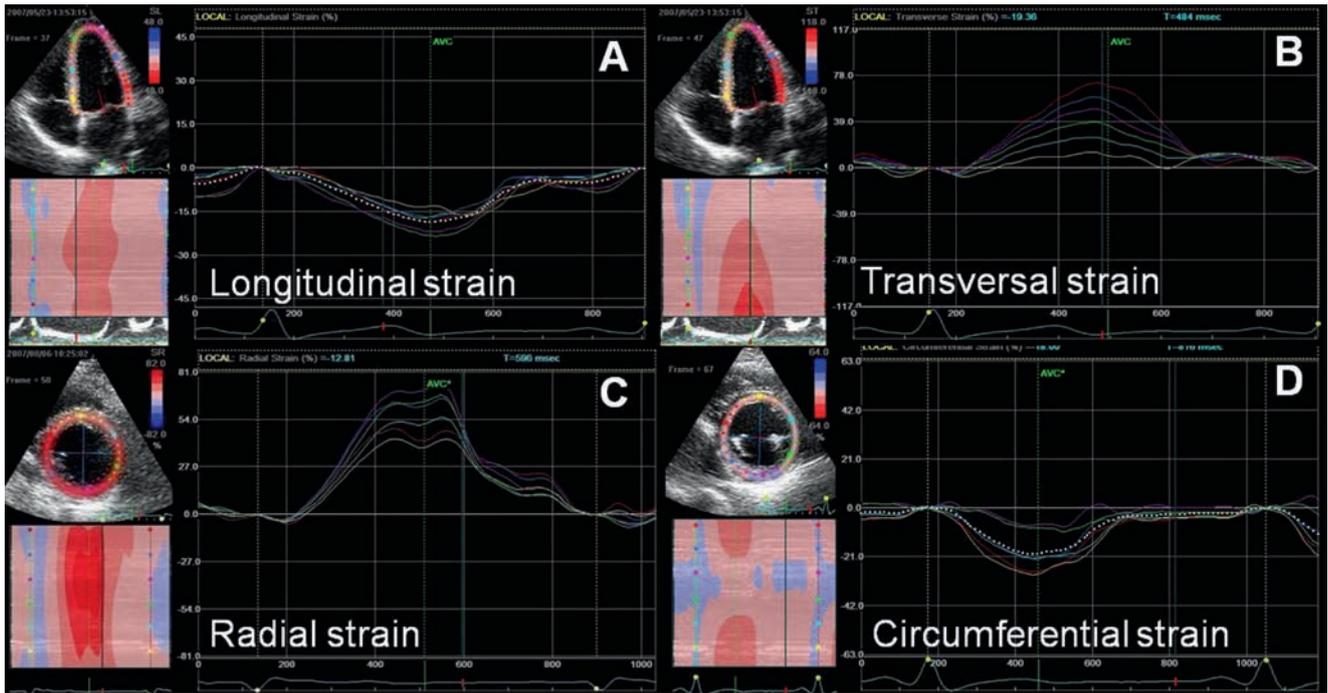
Speckle tracking echocardiography allows the assessment of strain in various directions independently on the angle of insonation. From apical views, both longitudinal (a) and transversal
